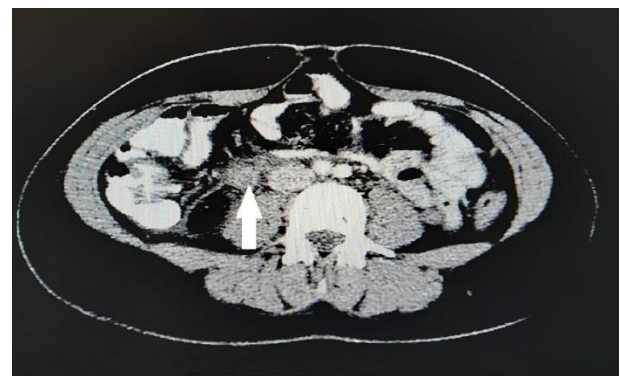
CT Angiography showing a thrombus in the right ovarian vein.
